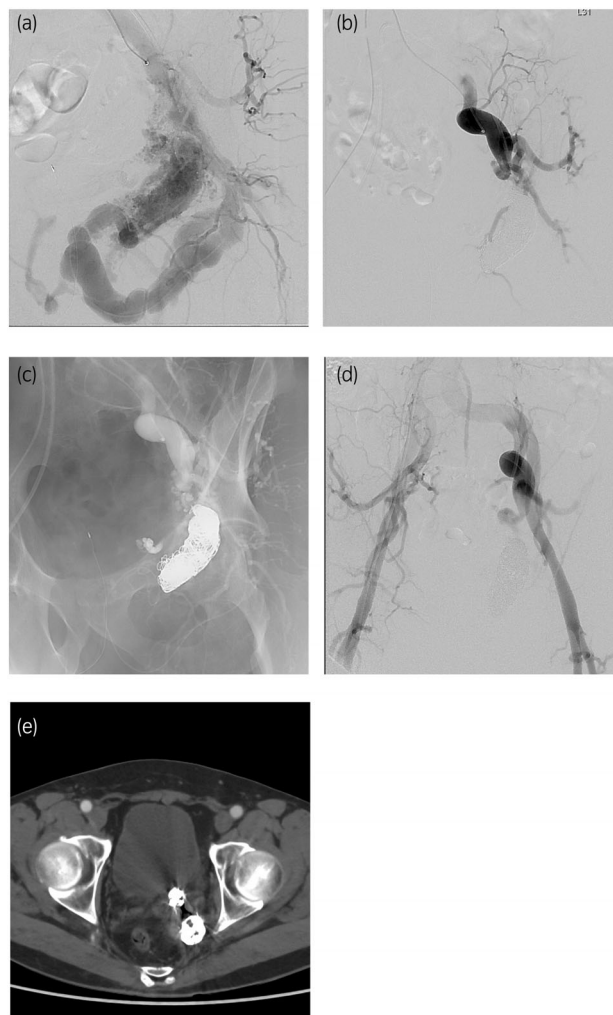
(a) Venous phase angiographic image before the third session. (b) The main shunt point at the top of the venous sac, embolized with dehydrated ethanol and coils. (c) Angiographic image showing the coils used during the third session. (d) Angiographic image after the third session, where the pAVM is no longer detectable. (e) Contrast-enhanced CT image of the pAVM after the third session. The pAVM involving the left seminal vesicle is not detectable.
